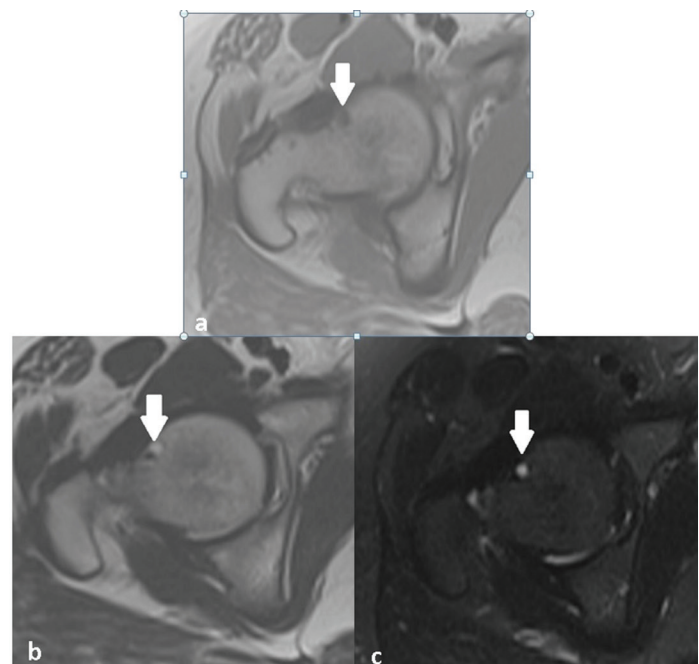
Axial T1-weighted image of MR showing the herniation pit at the femoral head-neck junction with low signal intensity (arrow) 1b and 1c. Axial T2-weighted and T2-weighted fat-saturated images of MR showing the herniation pit at the femoral head-neck junction with high signal intensity (arrow)
